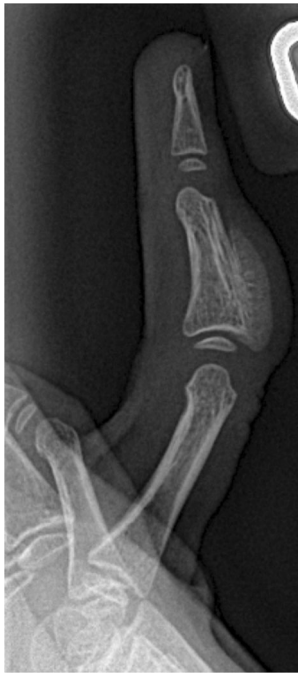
Radiograph at initial presentation
